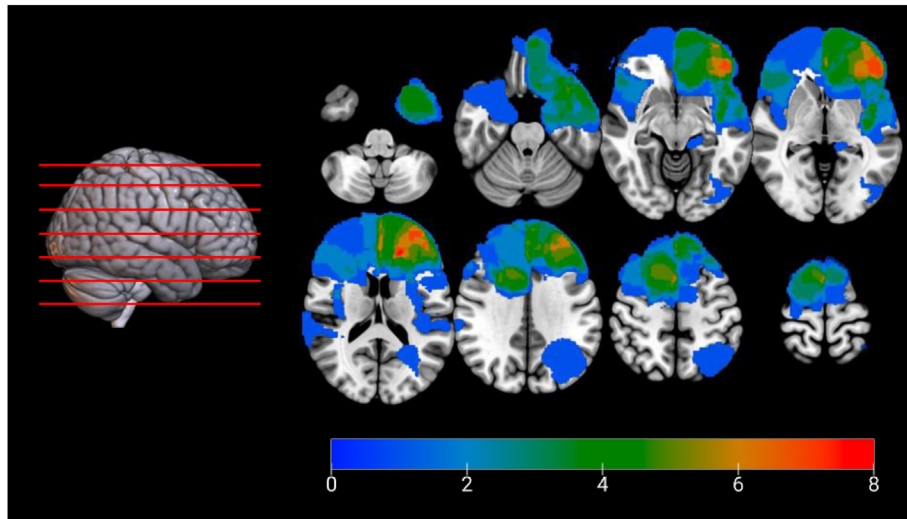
Overlap of brain lesions. Post-surgical brain cavities of the patients ($n = 29$) were normalized into the MNI space and overlapped on an MNI-normalized T1 MRI. Several axial slices are represented, corresponding to the red lines on the 3D brain representation. The radiological convention was used; hence left hemisphere is on the right side. The color bar indicates the number of patients with a lesion in this location (the warmer the color, the higher the number of patients).
